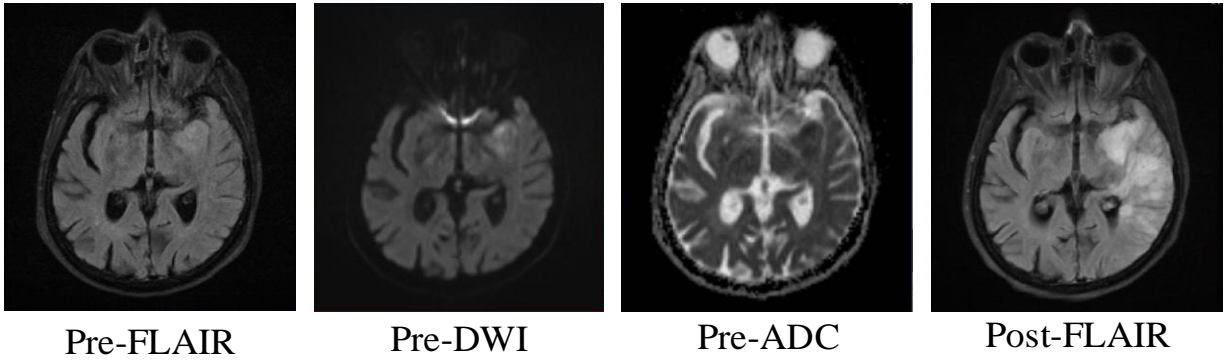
Imaging sequences for a patient with MCA (middle cerebral artery) stroke. Images include a pre-treatment FLAIR image (pre-FLAIR), pre-treatment DWI (pre-DWI), pre-treatment ADC map (pre-ADC), and a post-treatment FLAIR image (post-FLAIR).
